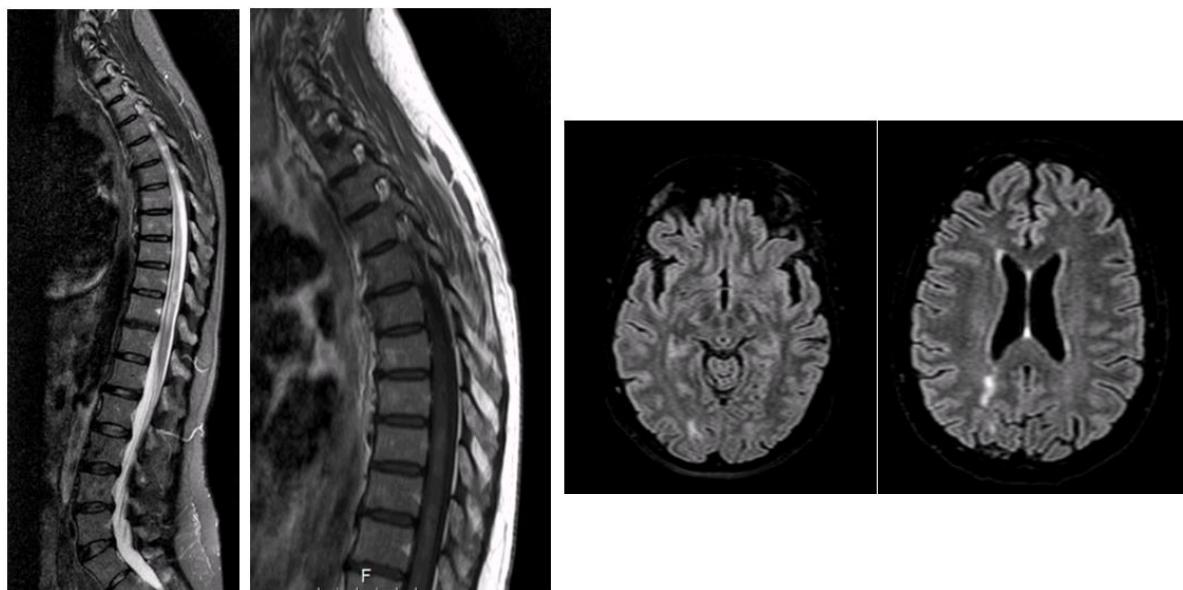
Spine MRI showing T2 hyperintense lesions from D5 to the conus (a), and in T1 sequence slight contrast enhancement (b); Brain MRI showing white matter lesions at admission on FLAIR sequence without restricted diffusion (c,d).
